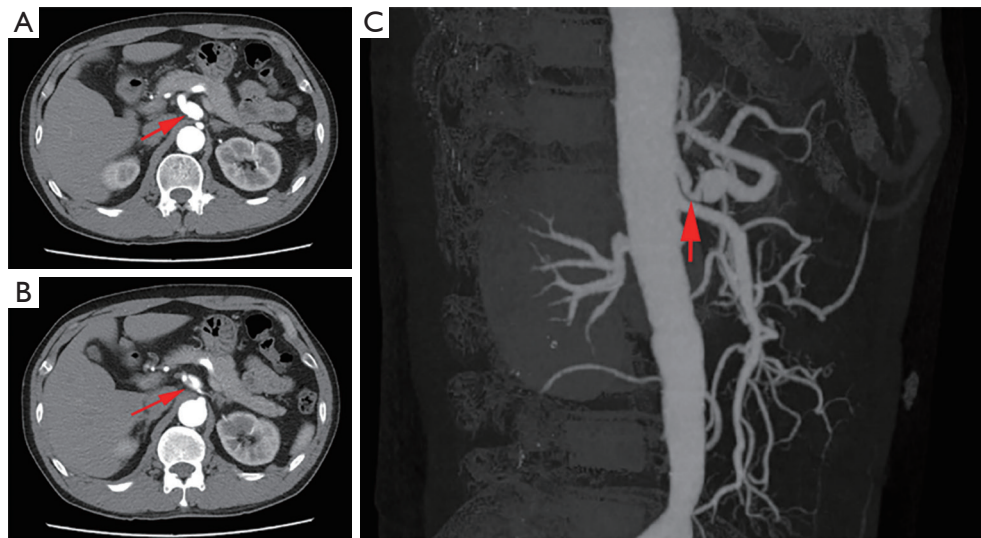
The CTA of ACTD caused by MALS. CTA demonstrated that the aneurysm was 15 mm in diameter and 22 mm long, 20 mm away from the origin of the celiac trunk without signs of calcification or thrombus, and the dissection did not extend beyond the celiac trunk. Arrow: (A) celiac artery aneurysm; (B) a small intimal tear at the site of focal celiac artery; (C) narrowing of the celiac artery. CTA, computed tomography angiography; ACTD, aneurysmal celiac trunk dissection; MALS, median arcuate ligament syndrome.
